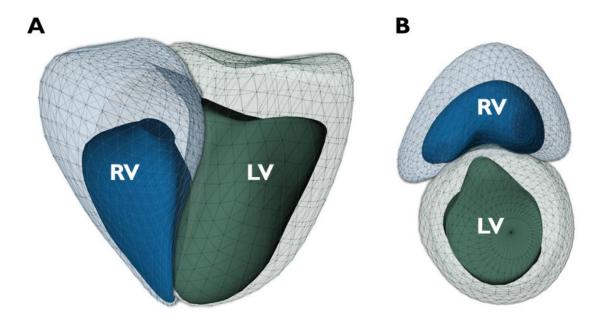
3D model reconstruction of left (LV) and right ventricles (RV) obtained from 3D echocardiographic datasets. A - long axis view. B - short axis view. (Own work)
